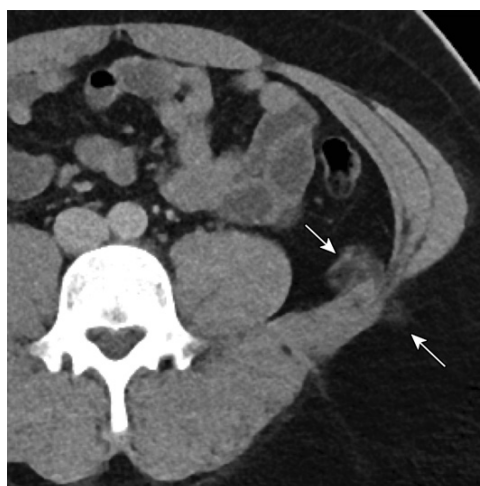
Subtle left-sided inferior lumbar hernia in a 34-year-old man after a motor vehicle collision. Axial CT image shows fat stranding (arrows) on both sides of the abdominal wall at the junction of the lateral abdominal wall musculature and the quadratus lumborum. This finding could easily be missed and has the potential to develop into a larger symptomatic hernia if not identified and treated.
